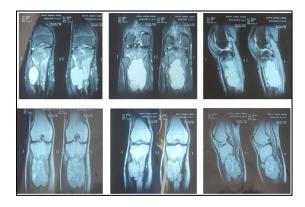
MRI showing exophytic growth in proximal tibia.
